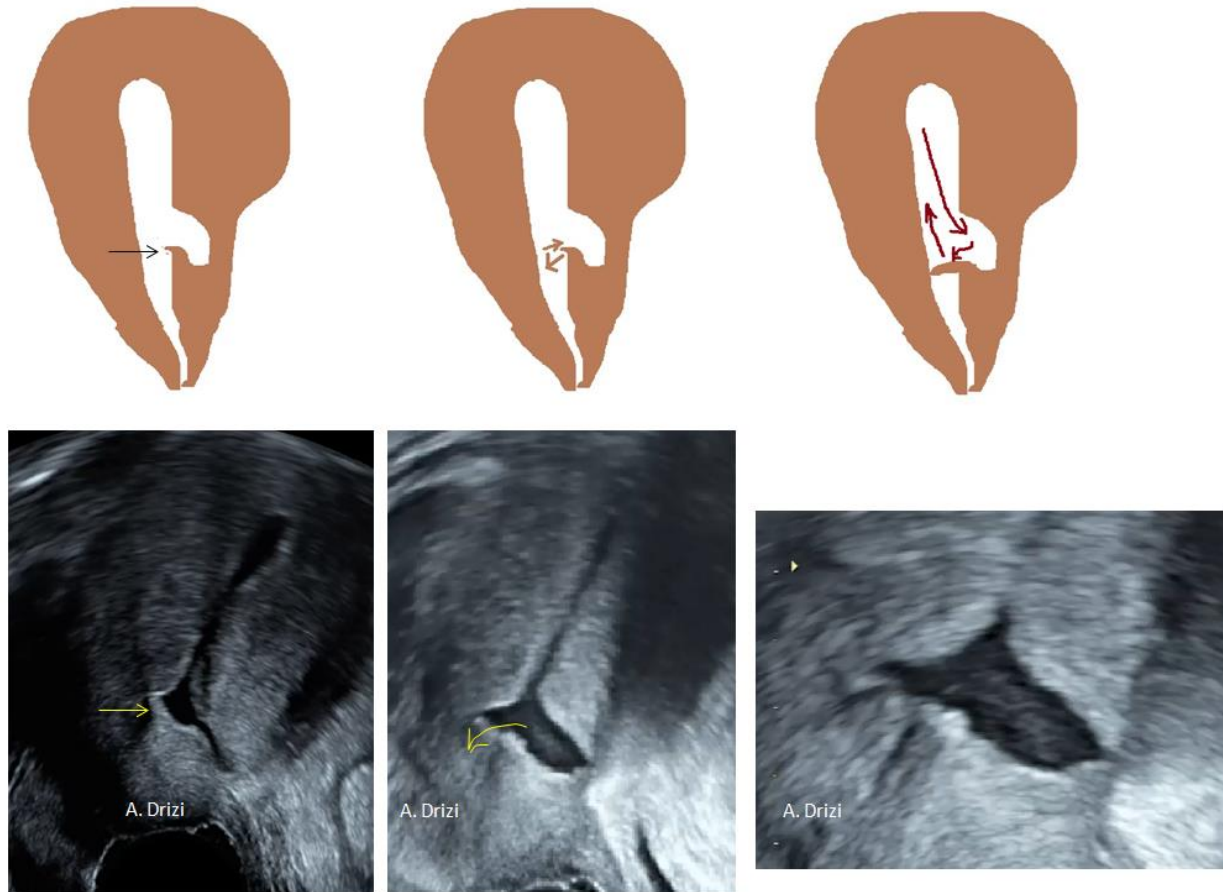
Demonstration of the valve mechanism by the distal edge and correlation with ultrasound at increasing magnification (black and yellow arrows). The flow of the blood closes the valve resulting in decreased evacuation of menses and causing more distention. Images by A. Drizi.
